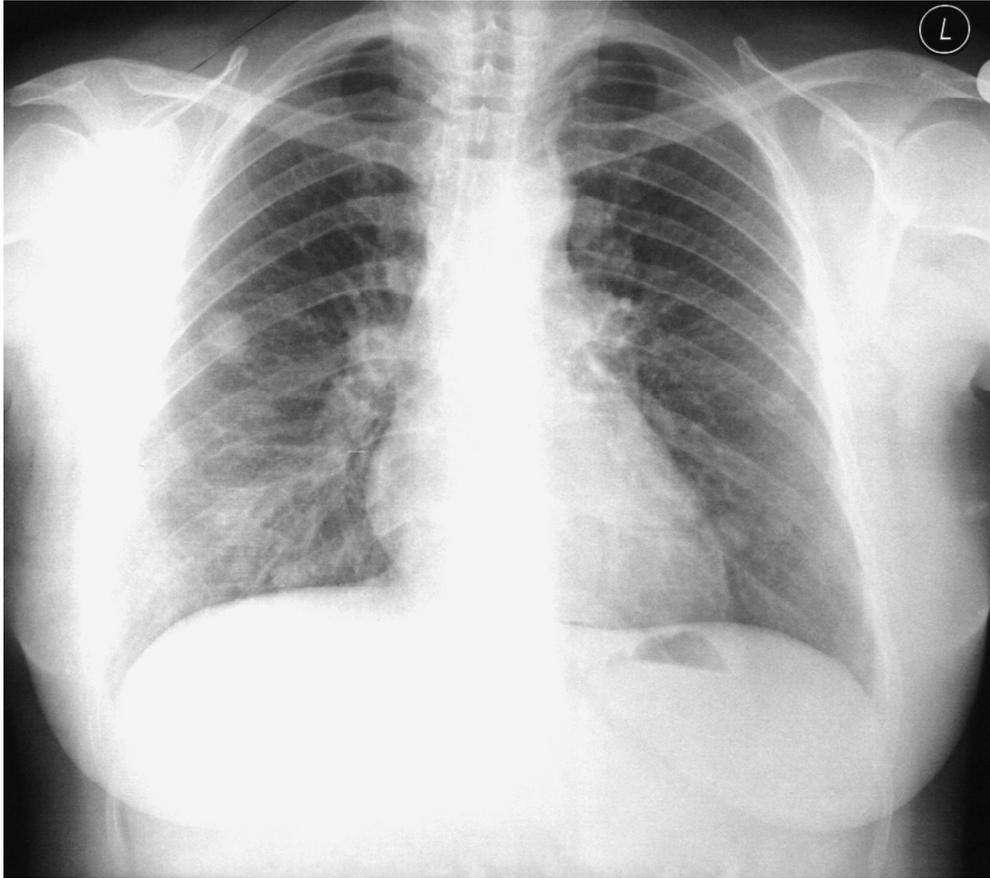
Posteroanterior radiograph of chest shows multiple bilateral nodules.
